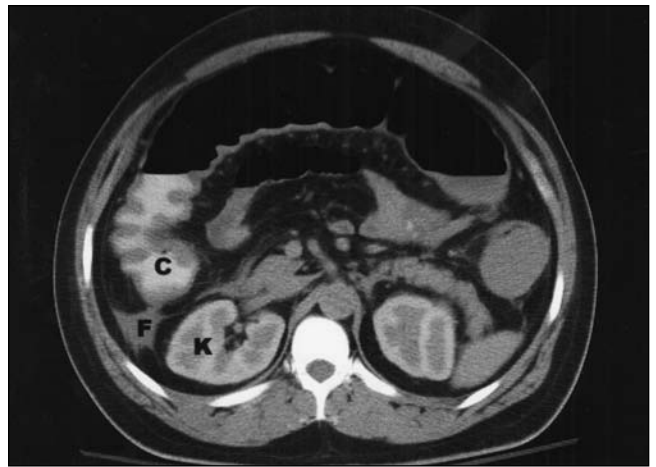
Noncontrast computed tomography (CT) of the abdomen demonstrates colonic dilation and diffuse wall thickening in the ascending and transverse colon (C) consistent with colitis. Fluid (F) is present in the right paracolic gutter. Retained contrast in the kidneys (K) from previous contrast CT indicates renal failure
